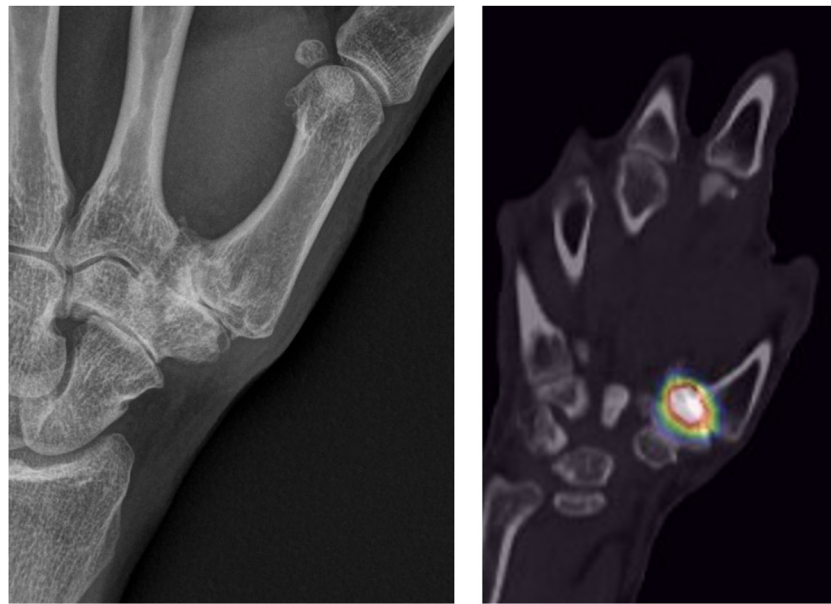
Radiographic view of pantrapezial osteoarthritis. Spect CT scan demonstrates only hypercaptation at the trapeziometacarpal joint without involvement of the STT joint.
